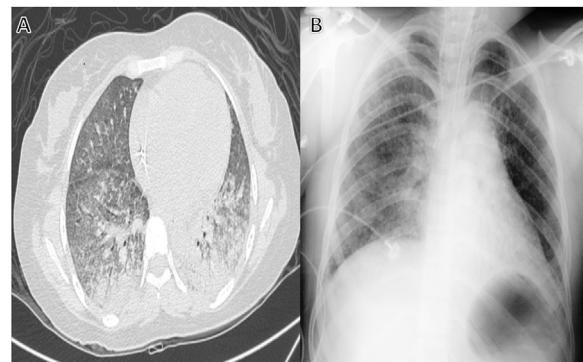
Chest computed tomography single phase and plain chest X-ray on post-ingestion days 7 (A) and 11 (B) respectively. Showed multiple micronodular and alveolar infiltrates disseminated of predominance toward the posterior regions of the basal lobes and bilaterally with areas of septal thickening.
